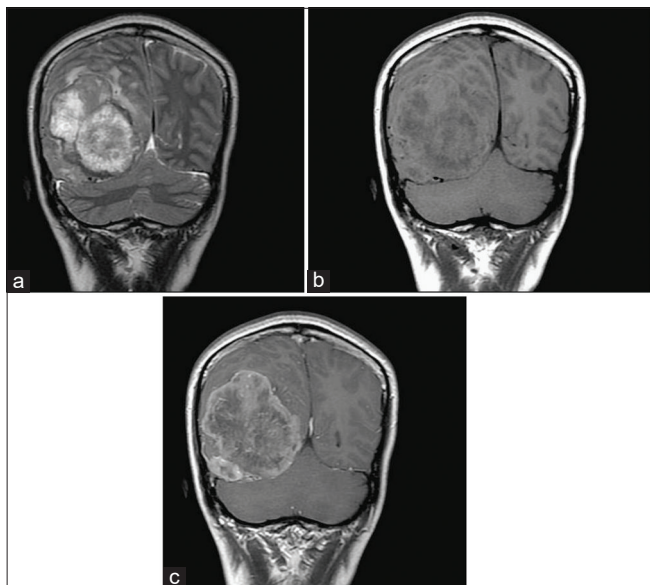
Preoperative brain MRI of case 3. Coronal axial T2-weighted image (a) and coronal T1-weighted image (b) showing a large tumor in right fronto-occipital-parietal region, abutting the posterior cerebral falx and right-sided tentorium and invading right occipital bone, isointense with cortical gray matter on T1-weighted image but hyperintense on T2-weighted image. Coronal T1-weighted image postgadolinium enhancement (c) showing heterogeneous enhancement.
